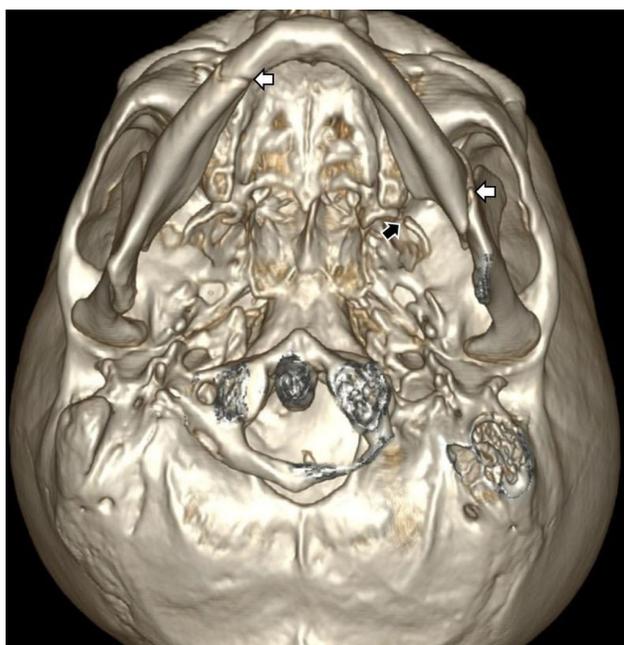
A 44-year-old man with displaced mandible fracture. Reformatted axial oblique CT image reveals fractures of the right basis and the left angle region of the mandible (white arrows). The left pterygoid plates are also fractured (black arrow).
